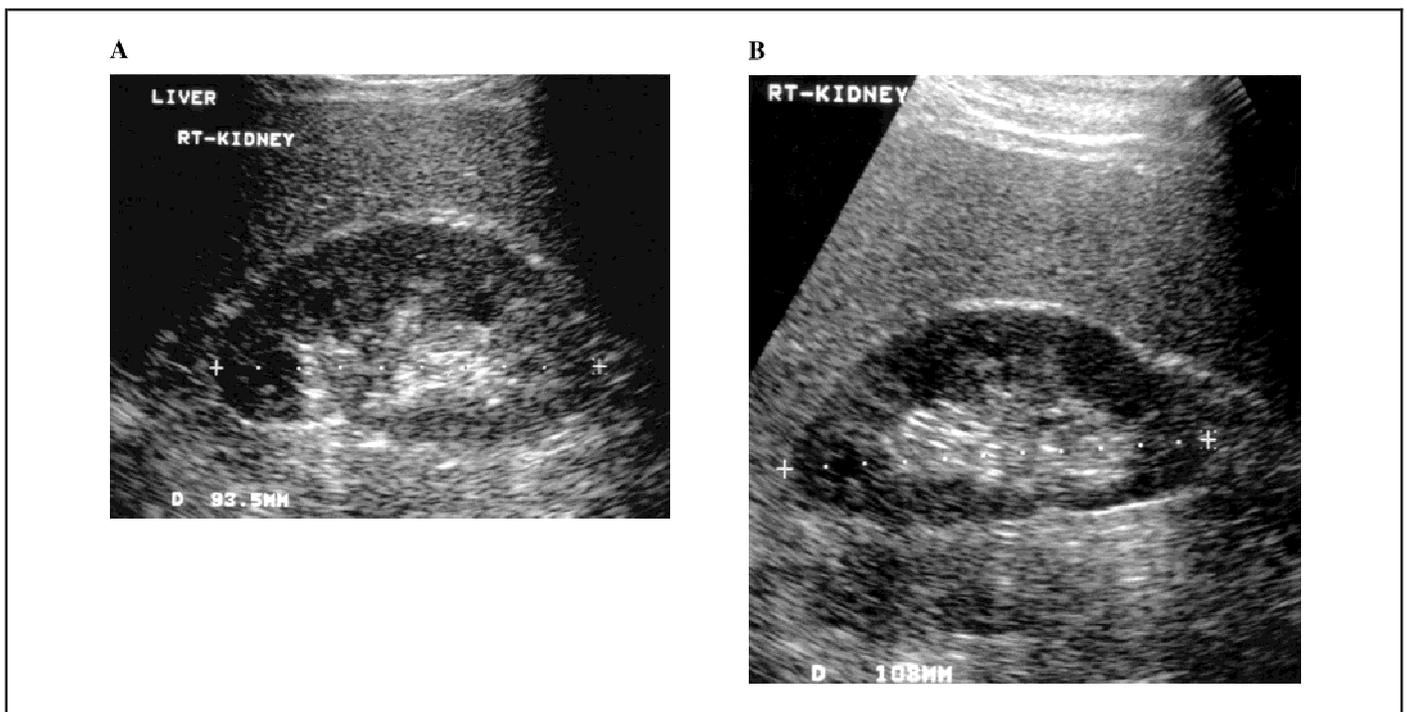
A) Ultrasound scan of a normal structure, the right kidney, which has been measured as 93 mm with the use of callipers. B) Ultrasound scan of the same kidney taken a few minutes later when it measures 108 mm. It appears to have increased in size by 16%. The difference is due to foreshortening of the kidney
